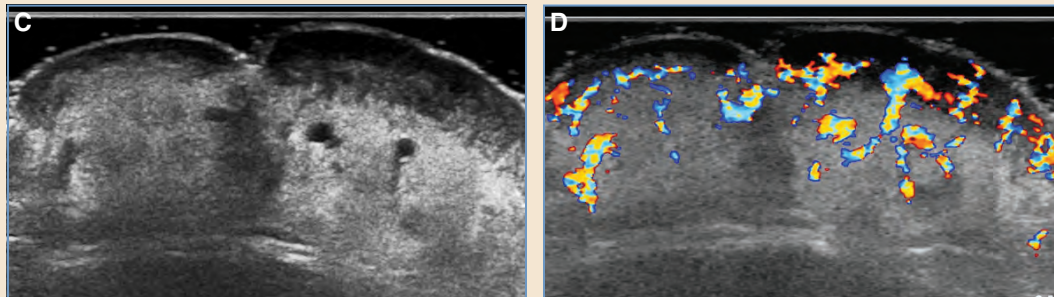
cont'd C, Increased reflectivity to the base of the lesion in the subcutaneous tissues resulting from fibrofatty changes. D, Reduced hypervascularity and vessel density during involution on color Doppler.
